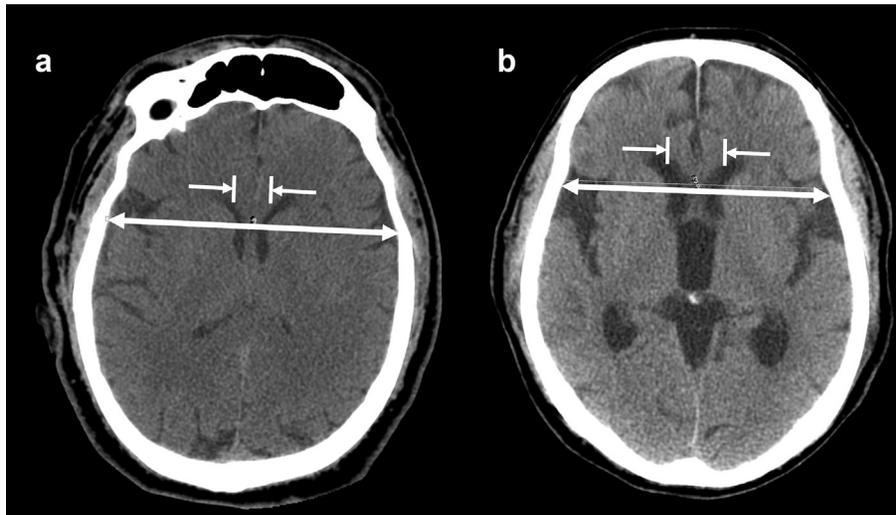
Cranial CT assessment of brain atrophy index. The brain atrophy index is measured by the ratio of the width of two lateral ventricles at the head of the caudate nucleus (also described at the intercaudate distance, denoted by two vertical lines between inward pointing arrows) to the width of the skull (denoted by outward pointing arrows). Measurements are taken at the cranial-caudal level of the fornix. (a) Normal brain atrophy index and (b) increased brain atrophy index.
